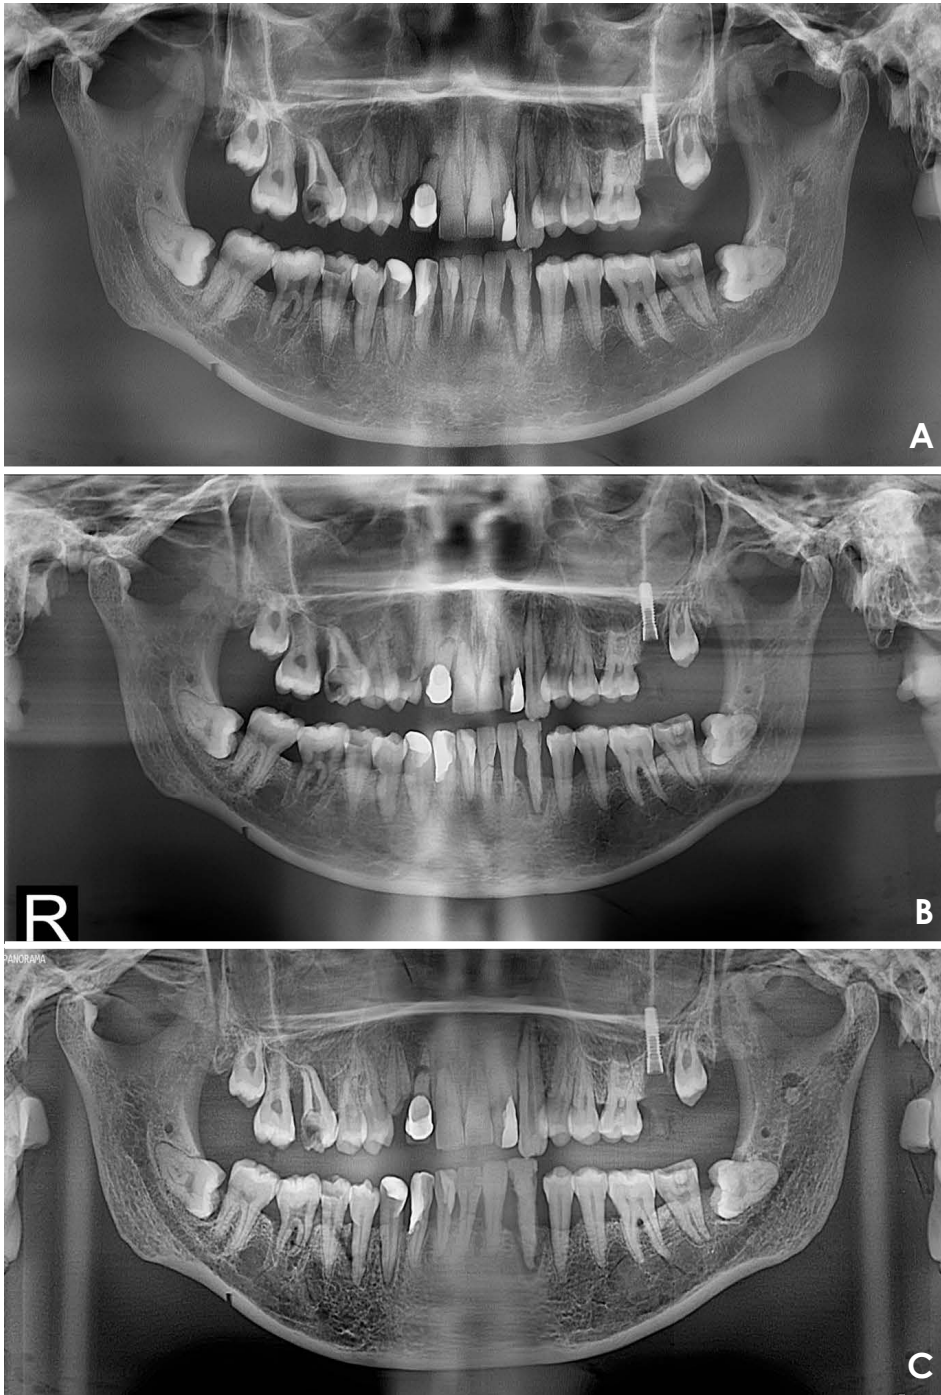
The panoramic radiographs obtained with the 3 devices provided a high level of diagnostic capability for the lesions. A. PCH-2500 (Vatech, Seoul, Korea). B. T1 (Osstem, Seoul, Korea). C. Eco-X (HDX, Seoul, Korea).
